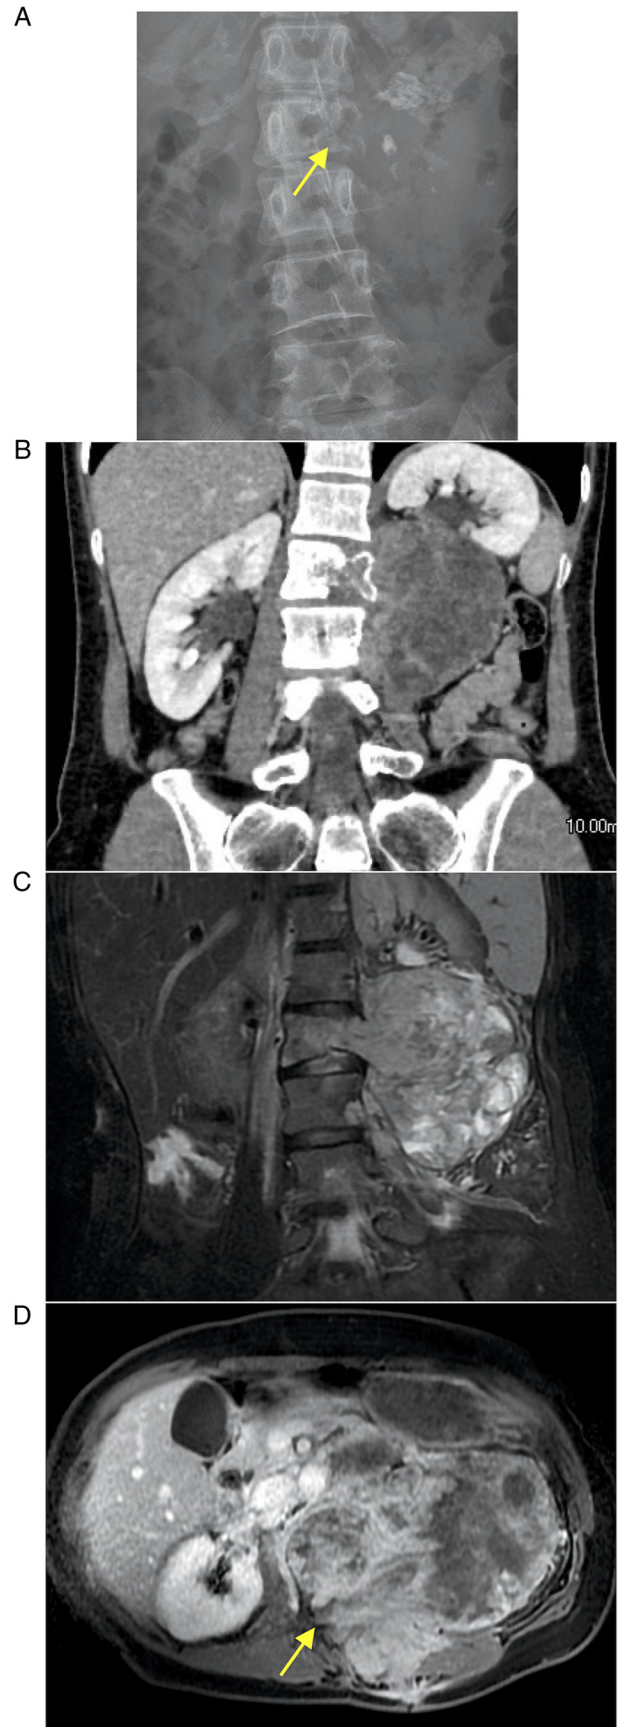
Imaging findings at the time of the initial diagnosis showed (A) canonical pedicle sign on the left side of the vertebra at L2 on a plain radiograph (arrow), (B-D) a massive neoplasm located mainly in the left paraspinal region at L2-L3 and destruction of the L2 vertebra on (B) computed tomography and (C and D) magnetic resonance imaging, and (D) invasion of the tumor into the spinal canal (arrow).
